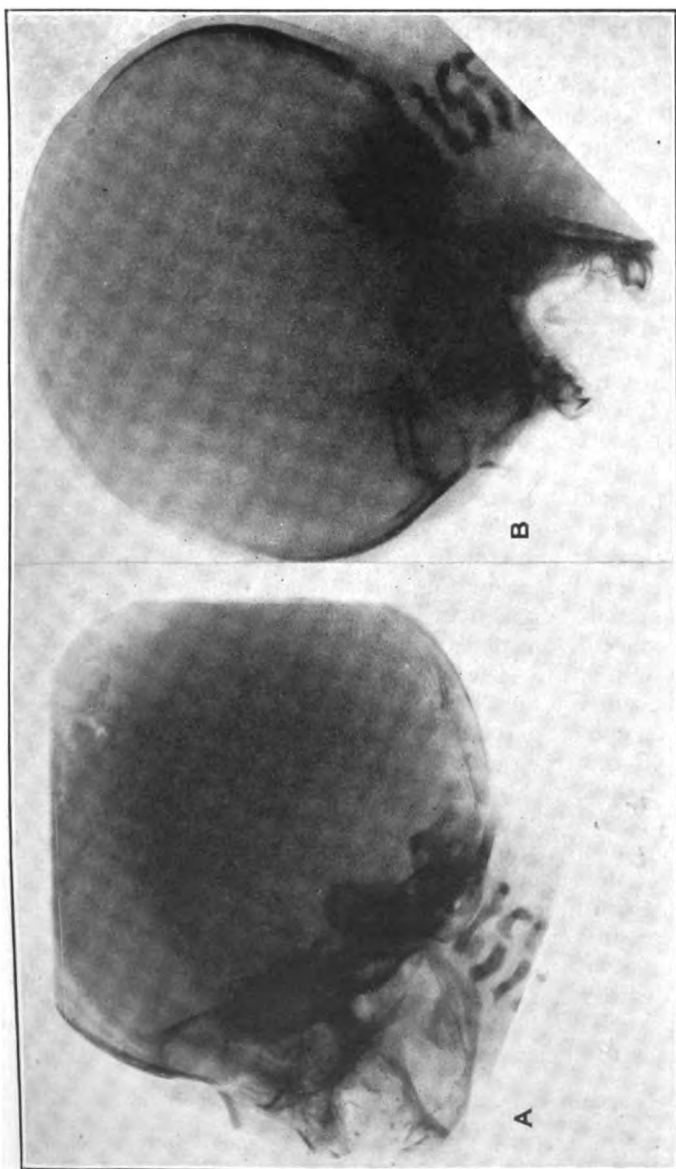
Roentgenograms of skull of fetus showing ossification centers at (a) twenty-nine to thirty-two weeks and (b) thirty-three to thirty-six weeks, three-fourths size.
